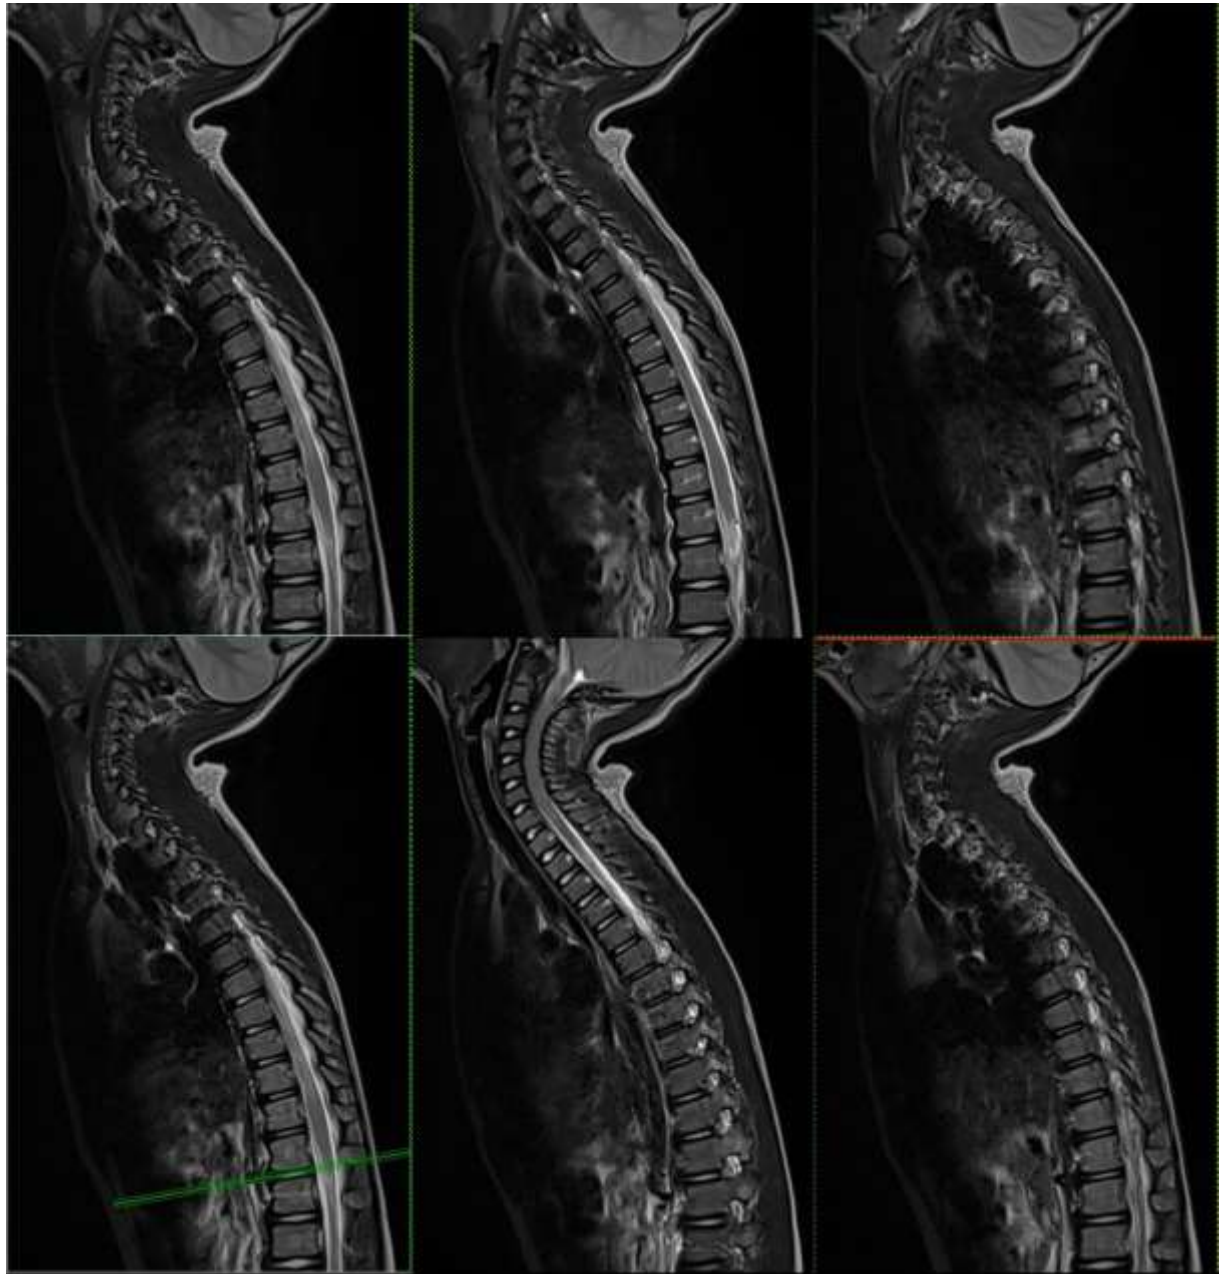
Spine MRI of Thoracal and Lumbal
